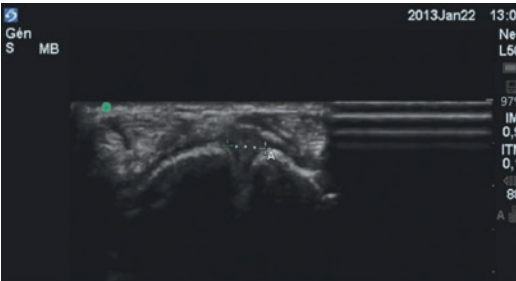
Ultrasound cross section of the scapholunate ligament (Edge, Sonosite 6–15 MHz)
